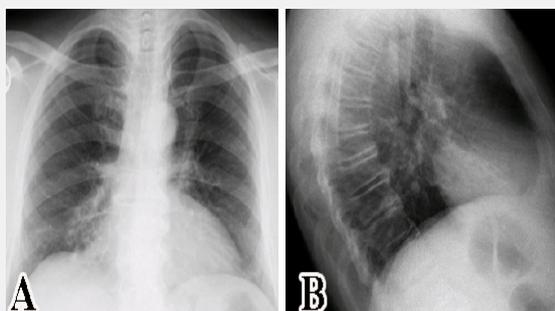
A. Preoperative PA chest X-Ray; B. Preoperative lateral chest X-Ray.
